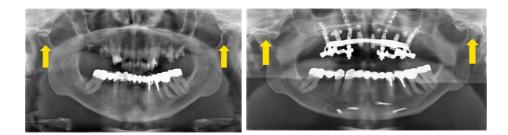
Preoperative orthopantomography (OPT). Decayed maxillary teeth and noncentric anterior position of the mandibulary processus due to protrusion
